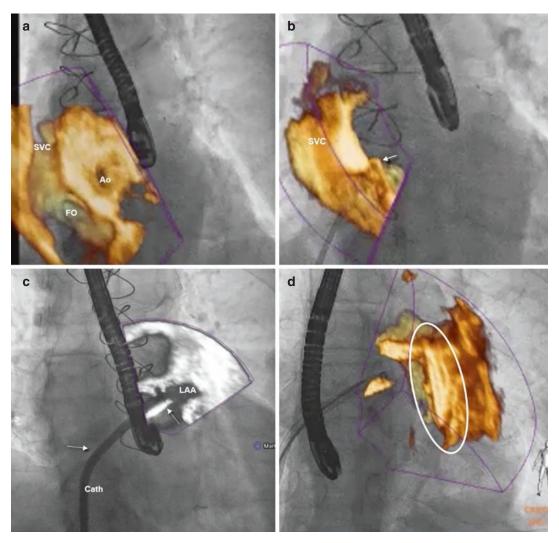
X-ray-echo fusion imaging of consecutive steps of the LAA occlusion. (a) Delineation of fossa ovalis (FO) and superior vena cava (SVC), (b) catheter inside
